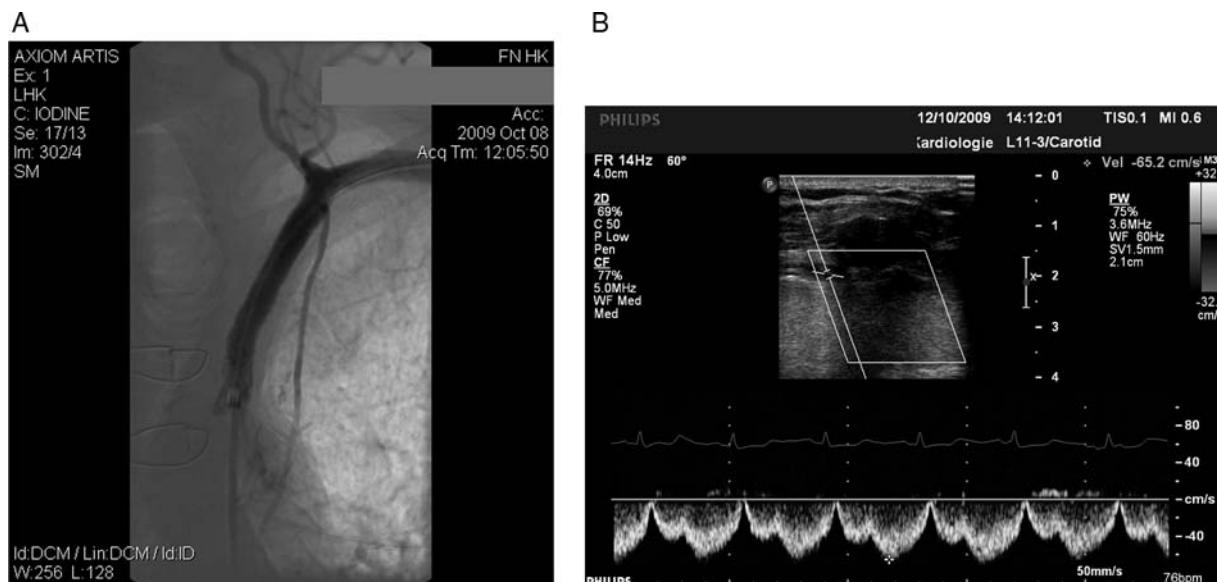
(A) Angiogram of the left subclavian artery (LSA) and its branches after successful angioplasty LSA with two stents; ortograde flow in LIMA–LAD graft and left vertebral artery is present. (B) Doppler ultrasound image of the proximal left mammary artery to left anterior descending artery graft after LSA angioplasty; small systolic and prominent diastolic ortograde flow indicating normal function of the patent LIMA–LAD graft (compare with Figure 1A).
